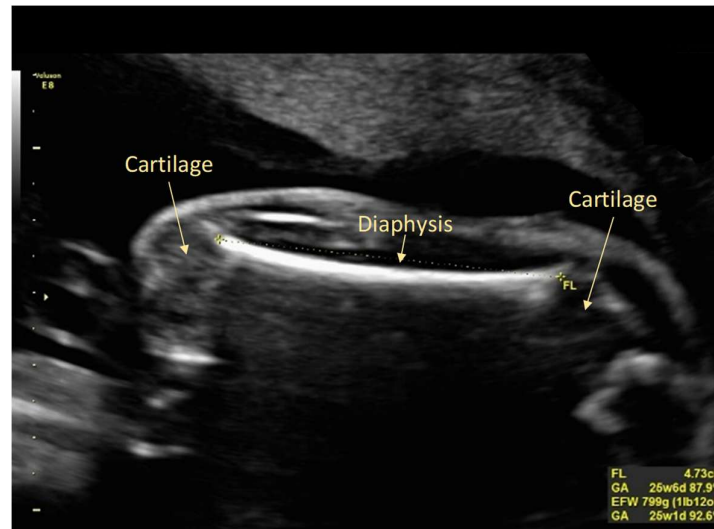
Fetal thigh imaged with contemporary ultrasound equipment at the imaging plane for the femur length. Note electronic 'on-screen' callipers and measurements displayed (bottom right corner) with equivalent gestational age and centiles for known gestational age. Image produced by D Paoletti.
